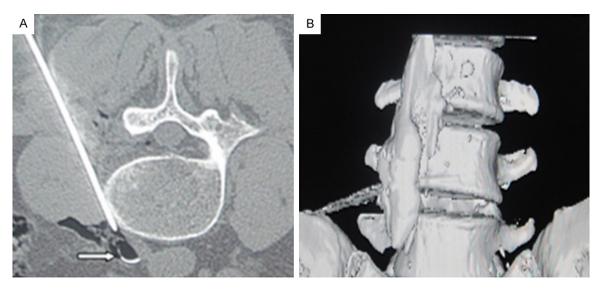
A: CT guided puncture of right lumbar sympathetic trunk (L4). Catheter with steel wire (the arrow) was inserted through needle; B: Contrast medium spread along L4 to L3 and L2 paravertebral sympathetic ganglion.
